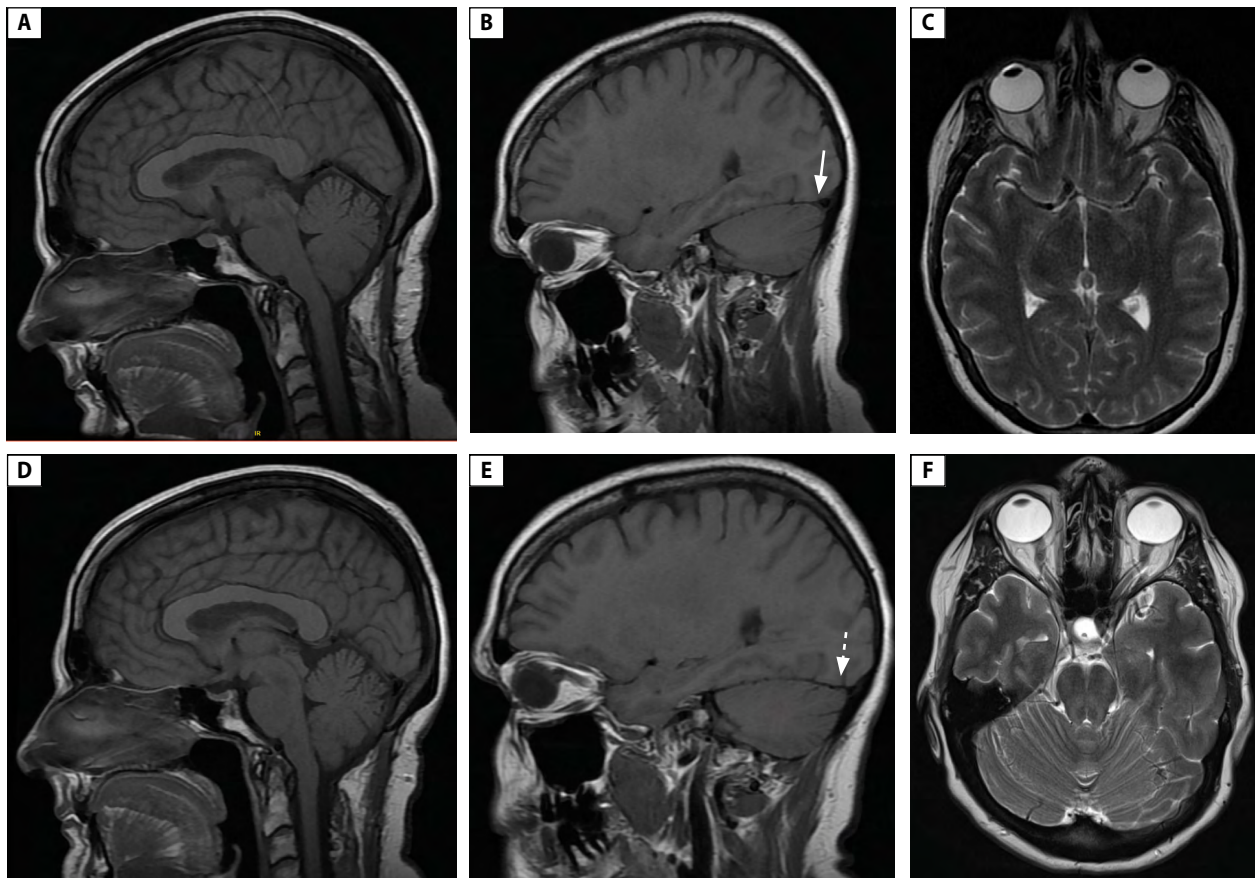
A patient with migraine was evaluated for daily left hemicranial headache after suffering a whiplash injury. History revealed intermittent clear rhinorrhea when bending over of 1–2 years' duration, unrelated to chief concern. Patient was suspected to have pseudotumour cerebri syndrome based on multiple radiographic stigmata of intracranial hypertension. However, lumbar puncture revealed an opening pressure of 8 cmH<sub>2</sub>O and there was no papilloedema. Image A: partially empty, expanded sella turcica; B: tortuosity of right optic nerve in vertical plane; C: bilateral transverse venous sinus stenosis; D: large right cribriform plate defect with meningocele and remodeling of ethmoid trabeculae (solid arrow); E: large right petrous apex and clivus osseous defect with meningocele (dashed arrow). Patient underwent endoscopic endonasal repair of right anterior cranial fossa for non-active CSF rhinorrhea one year after images were taken. Bolt intracranial pressure monitoring performed four months after surgery confirmed nocturnal intracranial hypertension (normal pressures while awake) with average overnight intracranial pressure of 26.6 cmH<sub>2</sub>O and maximum intracranial pressure of 31.38 cmH<sub>2</sub>O. Intracranial pressure normalised after intravenous administration of acetazolamide 500 mg. The most likely aetiology of intracranial hypertension in this case was bilateral primary venous transverse sinus stenosis in combination with untreated sleep apnoea. Patient continued on oral acetazolamide to prevent papilloedema and development of recurrent or new skull-based CSF leak
